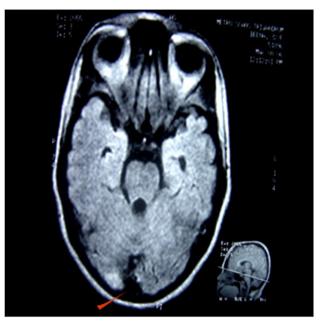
MRI shows flair axial section showing two hyper-intense lesions in the left occipital lobe
